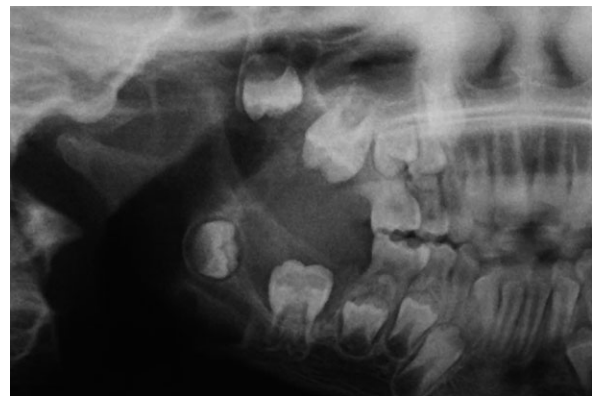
Panoramic radiography details. Large radiolucent area in the right mandible, deformity of the condylar head, and displacement of the first molars.
